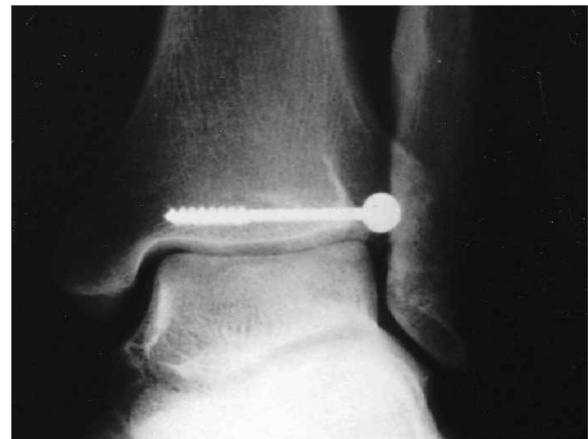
One year post-operative AP X-ray view showing proper union without arthrosis.
